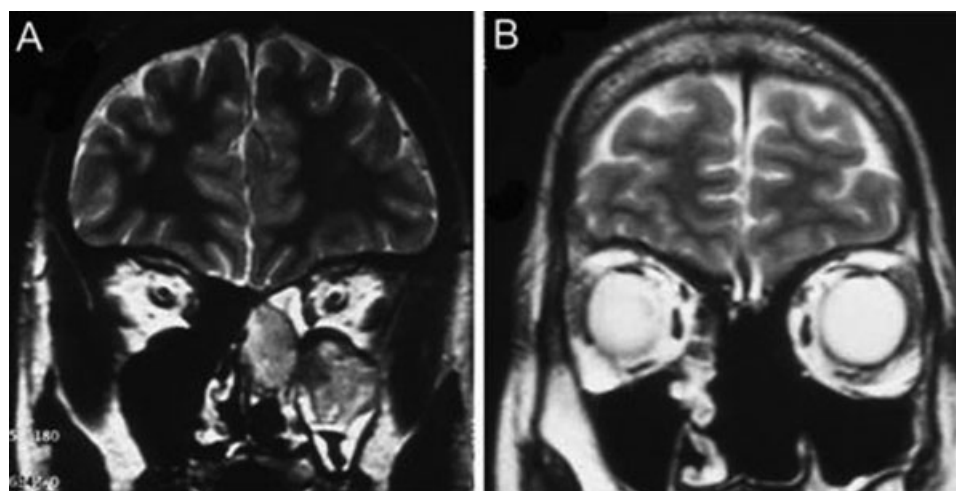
(A) Preoperative T2-weighted coronal MR image showing a tumor formation within the left ethmoid and maxillary sinus. (B) T2-weighted coronal MR image 7 years after endonasal tumor resection without sign of recurrence.
